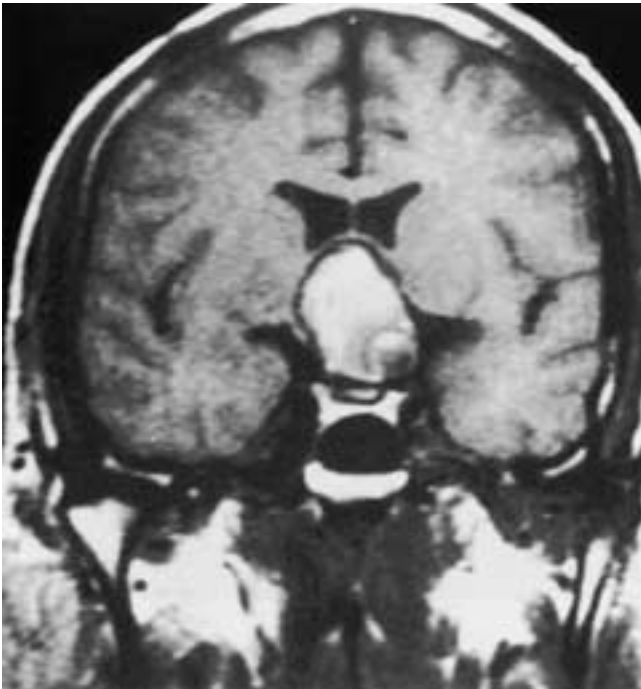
Thrombosed aneurysm. Coronal T1-weighted image shows a suprasellar mass composed of high signal intensity methemoglobin.
